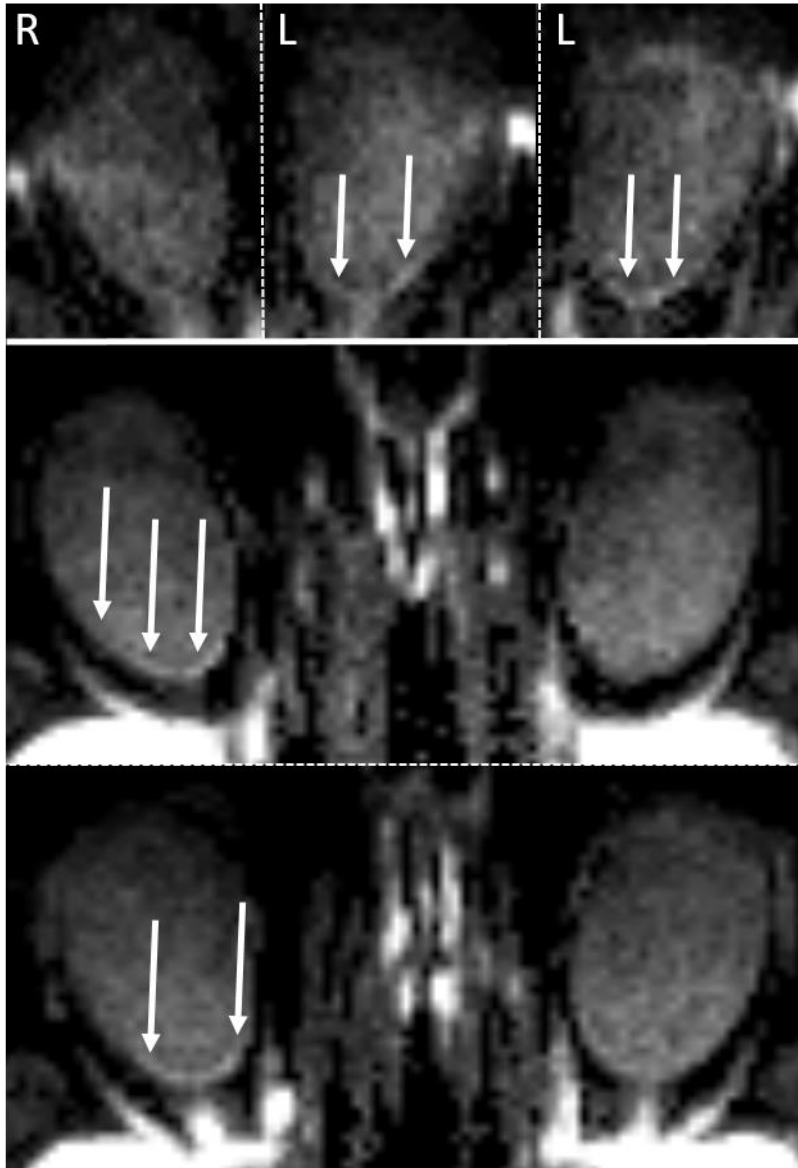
Examples of subtle DWI findings on 3T DWI-EPI MRI in acute CRAO ($b=1000$ s/mm² images). ADC maps were rated unremarkable (not shown). Top row: Subtle retinal DWI hypersignal is noted on two adjacent slices in this case of left-sided CRAO. Both readers scored this finding. Lower rows: Subtle retinal DWI hypersignal is noted on two adjacent slices in this case of right-sided CRAO. Only the more experienced reader scored this finding.
